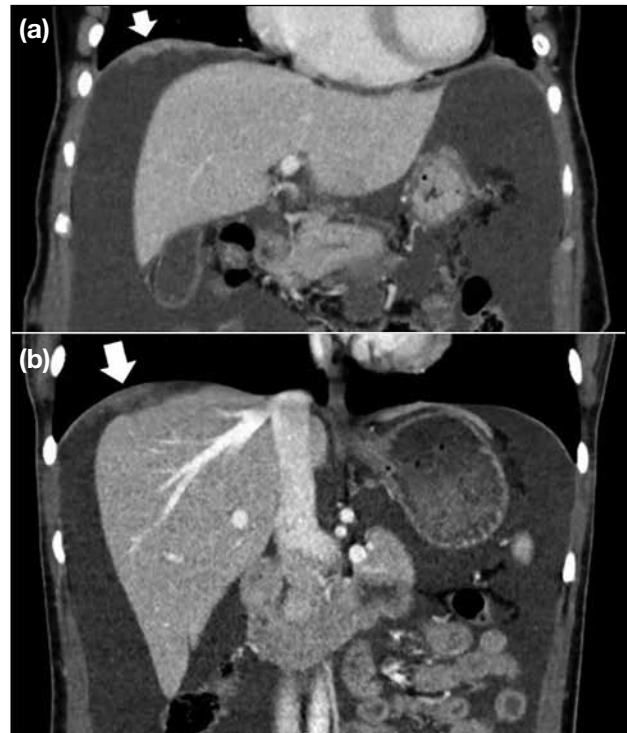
Contrast computed tomography images demonstrating right subphrenic deposits (arrows in [a] and [b]) that are best appreciated on coronal image. (b) Larger subphrenic deposits can cause scalloping of liver contour.
